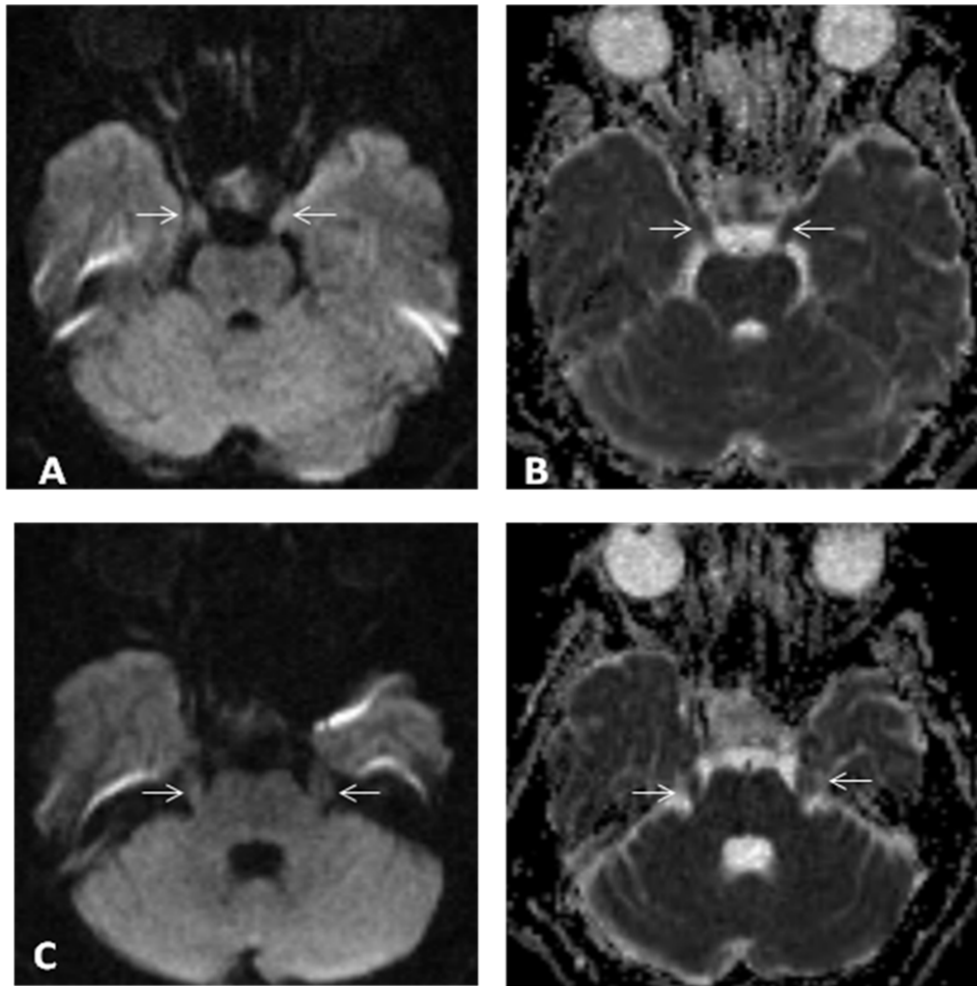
DWI (A, C) with corresponding ADC map (B, D) shows diffusion restriction along the oculomotor (arrows on A and B) and trigeminal nerves (arrows on C and D) bilaterally
